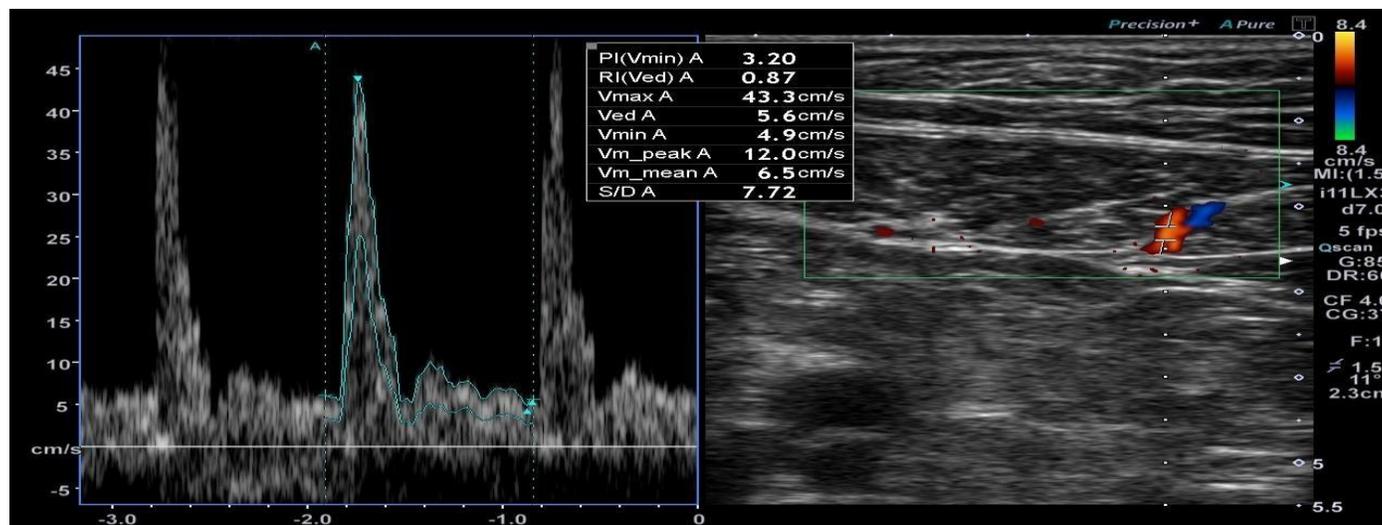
Duplex ultrasound of a perforator artery of a patient with acute appendicitis. The waveform analysis showed a peak systolic velocity of 43.3 cm/s, a pulsatility index of 3.20, and a resistance index 0.87.
